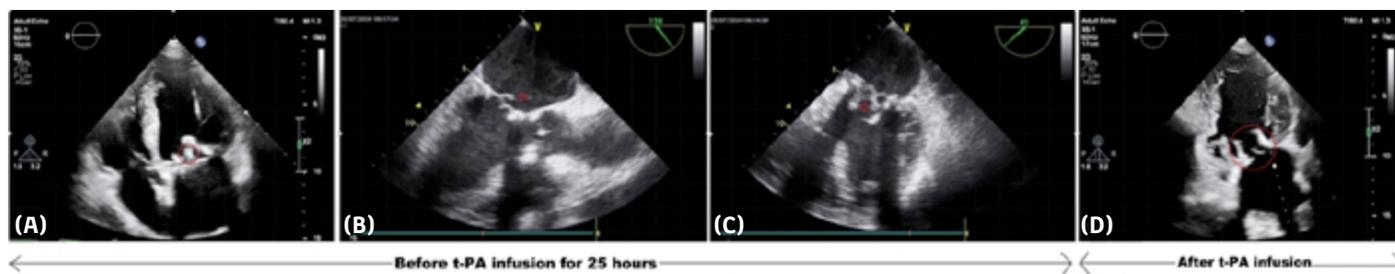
Transthoracic echocardiography (A) and transesophageal echocardiography (B-C) showed a hyperechogenic, mobile mass on the posterior leaflet of the bioprosthetic mitral valve 24 hours after edoxaban interruption. The mass disappeared following ultraslow tissue plasminogen activator (tPA) therapy (D).
